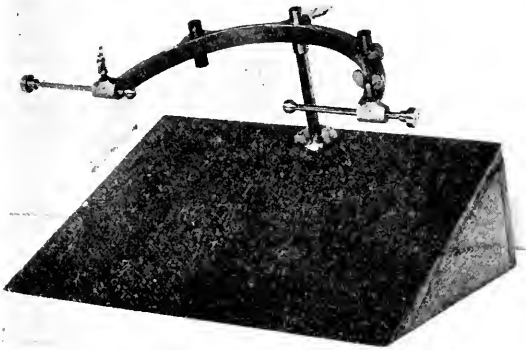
Head-rest for radiography of the accessory sinuses.
